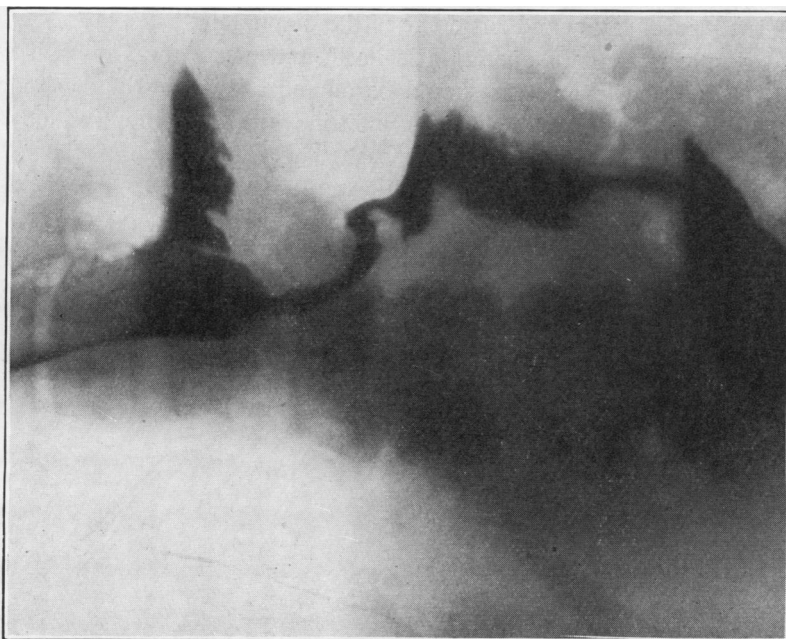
Case 2. Radiograph after oesophago-jejunostomy. Some barium passes through the stricture into the stomach. The loop of intestine above the diaphragm is beginning to fill.
